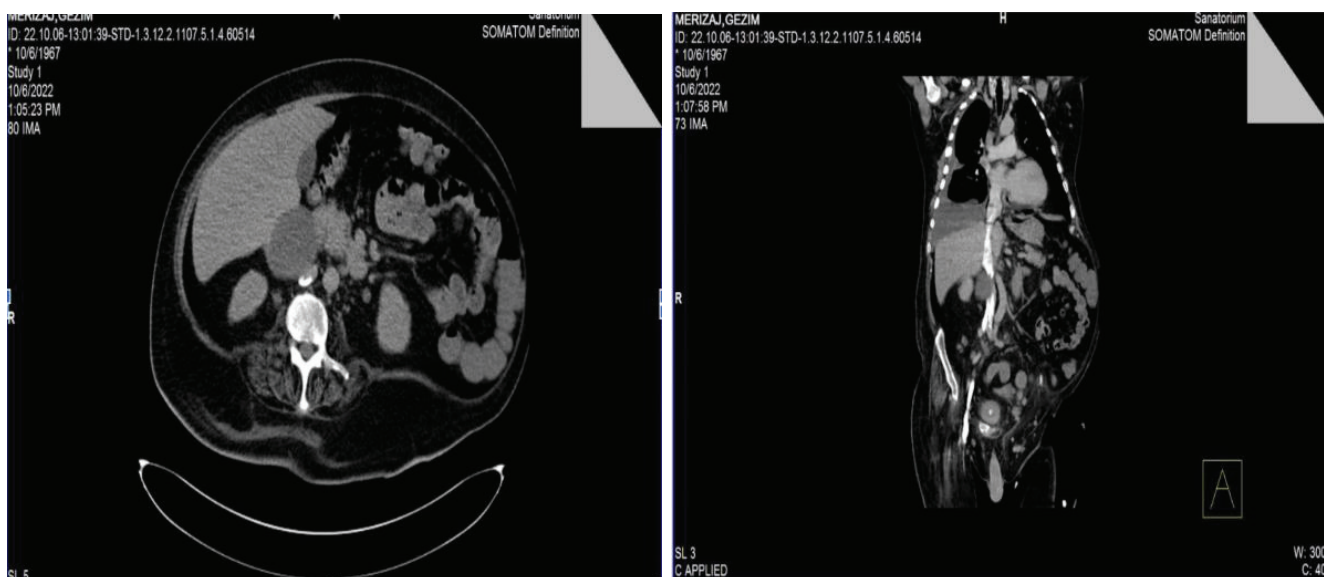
Axial contrast CT scanner and sagittal view of patient's abdominal cavity demonstrating cystic mass in caudal lobe with "effect mass" on IVC.
